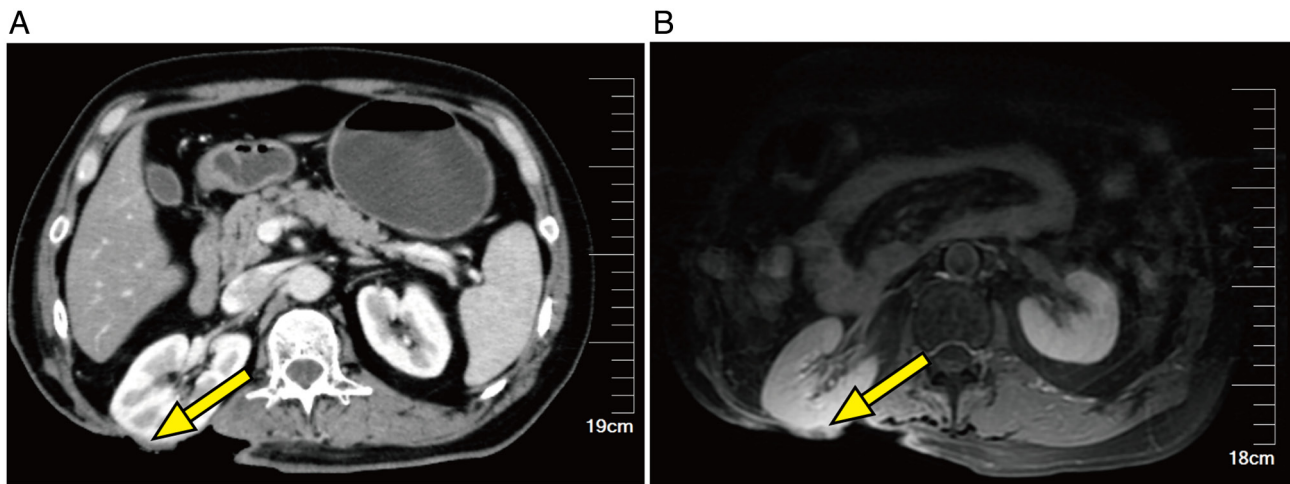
Imaging follow-up after anlotinib initiation. (A) Magnetic resonance imaging at 2 months after anlotinib showed no identifiable residual tumor mass at the primary site. (B) Computed tomography at 2 months after anlotinib confirmed sustained tumor regression.
